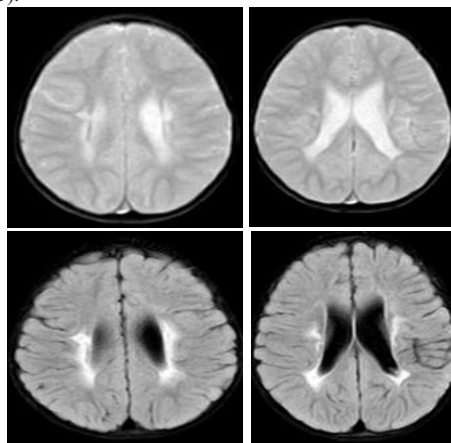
Preterm, low birth weight infant MRI brain showing - perirolandic, periventricular and peritrigonal hyperintensities in T2 WI (a, b) and FLAIR (c, d) images – suggesting hypoxic ischemic encephalopathy.
